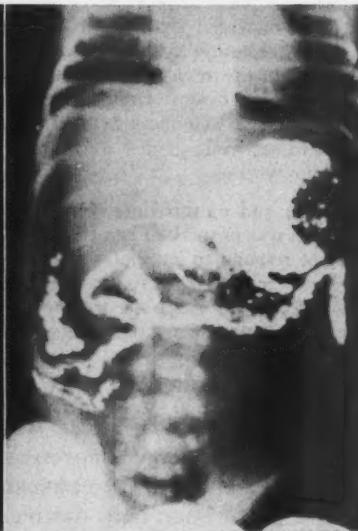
Anterior posterior roentgenogram showing opaque oil free in peritoneal cavity. Oil was given through esophageal catheter and was seen to escape from the stomach or duodenum at fluoroscopy.
